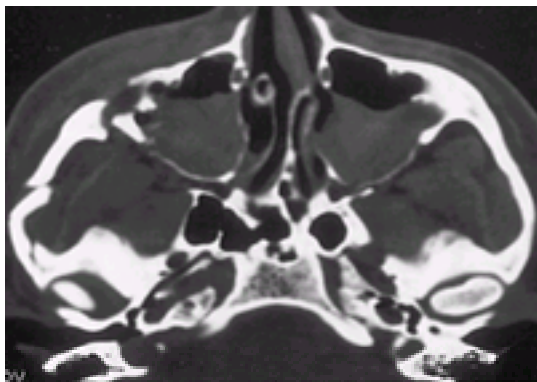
Axial computed tomography scan of the midface on a patient with a right zygoma fracture. Note the buckling of the zygomatic arch, the fractures of the zygomaticomaxillary and zygomaticotemporal areas, and the opacification of both maxillary sinuses.
